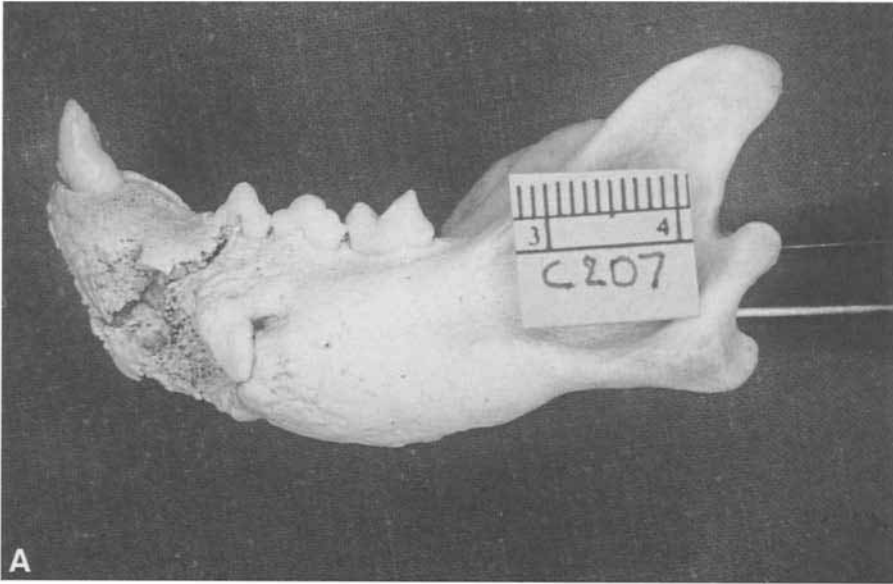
(A) Severe mandibular thickening with irregular new bone formation, suggestive of osteomyelitis; a complicated crown fracture with periapical lesions of CmandL, stage 3 periodontitis of P3mandL and stage 2 periodontitis of P4mandL were present. (B) Occlusal radiograph of the same case; the right mandible is also thickened and a complicated crown fracture (without periapical lesions) of CmandR is present.
